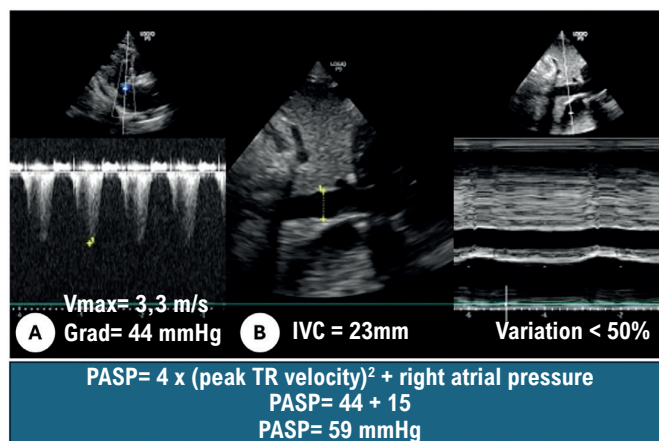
Estimation of PASP, measured at 59 mmHg in this patient. A) TR assessed with continuous-wave Doppler. B) Estimation of RAP by evaluating the diameter of the IVC and collapsibility with the respiratory cycle in M-mode. IVC: inferior vena cava; PASP: Pulmonary arterial systolic pressure; RAP: right atrial pressure.
